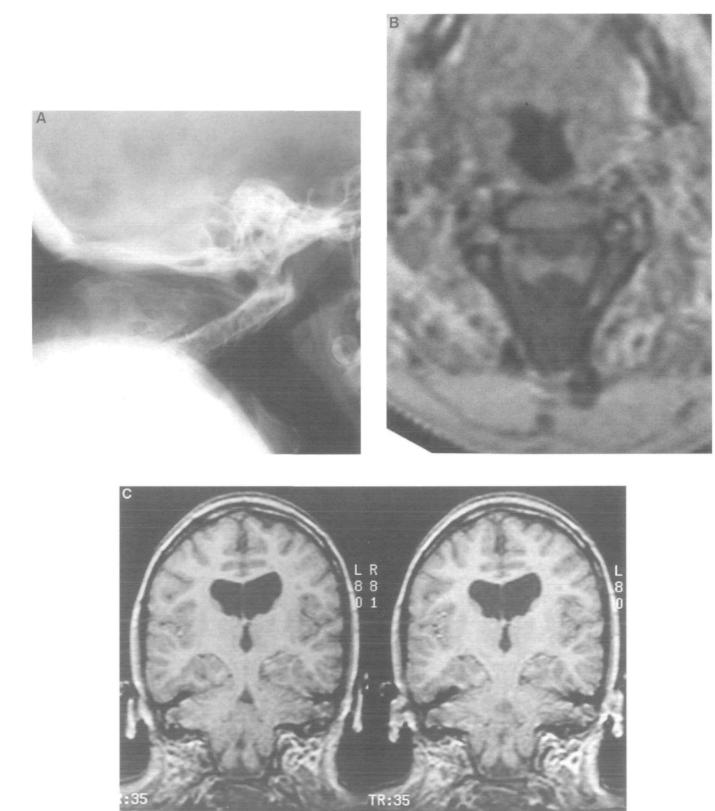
Case 4. (A) Lateral cervical roentgenogram showing total fusion of hypoplastic vertebral bodies and fusion of malformed posterior elements. (B) Axial and (C) coronal MRI (T_1 -weighted image) with dorsally split lower medulla and upper cervical cord. Note the wide spina bifida and the large dural sac on Fig. 4B.
